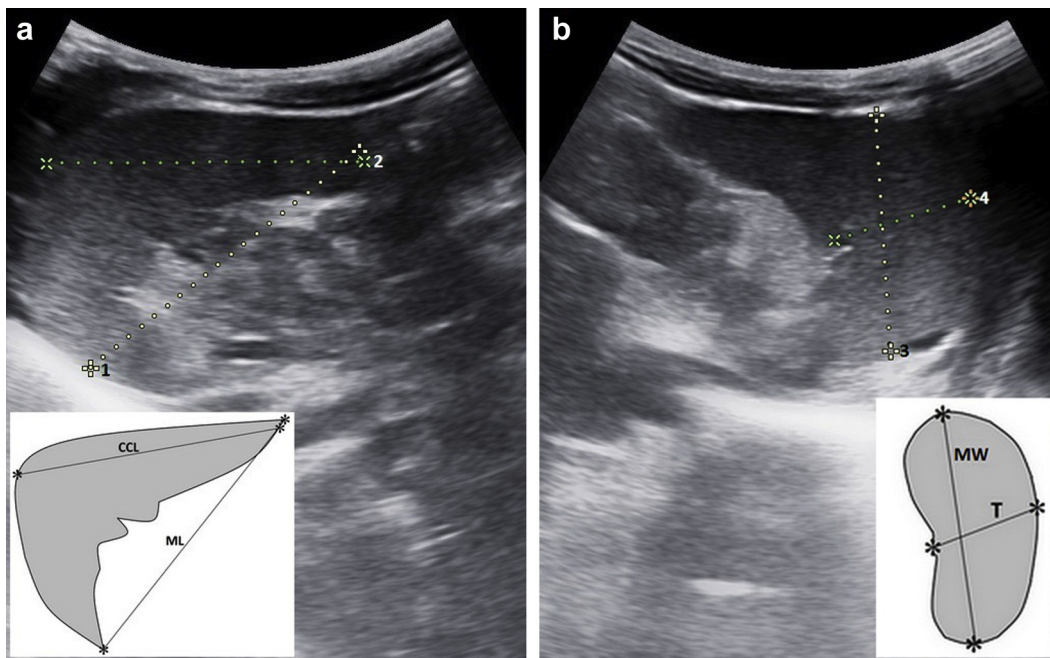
Sample longitudinal sonographic image depicting ML (dotted line 1) and CCL (dotted line 2) of the spleen measured as the optically maximal distance at the hilum between the most superomedial and the most inferolateral points and from the uppermost splenic margin to the lowermost splenic margin, respectively (a); A sample transverse sonographic image depicting MW (dotted line 3) and T (dotted line 4) of the spleen measured as the greatest overall dimension and the shortest distance between the hilum and the outer convex splenic surface, respectively (b). ML = maximum length; CCL = craniocaudal length; MW = maximum width; T = thickness.
